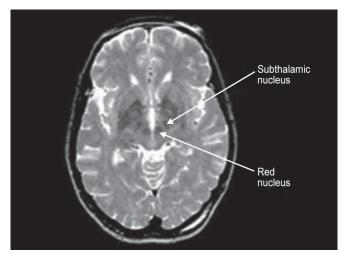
Location of STN and red nucleus in T2-weighted MRI
